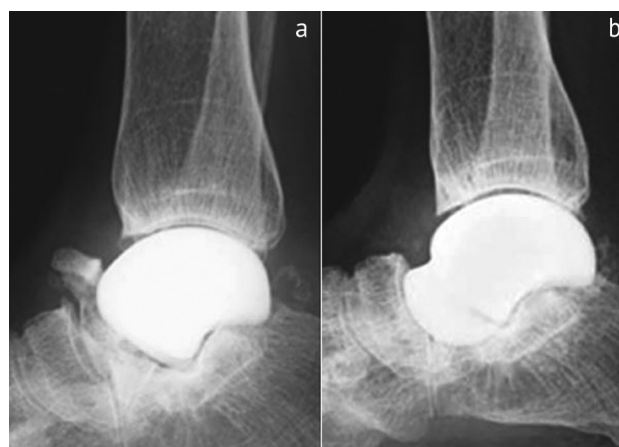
Radiographs of a 74-year-old woman with avascular osteonecrosis of the talus treated with a first-generation endoprosthesis: a 1.5 years after surgery, the image shows the remaining necrotic talus neck and head fracture due to loosening and subsidence between the components of the endoprosthesis and neck of the talus; b after revision with the use of a second-generation talar endoprosthesis, a total endoprosthesis [72]
